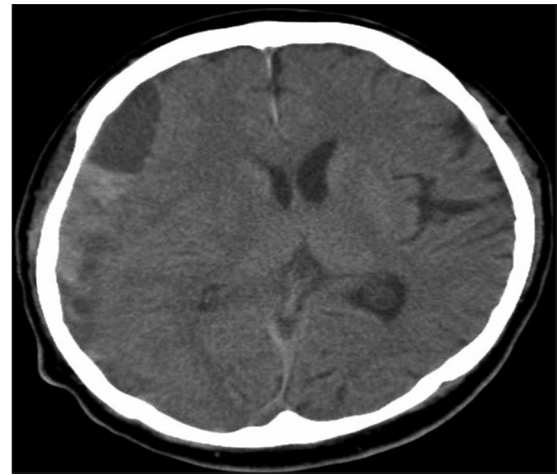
Axial noncontrast CT brain obtained preoperatively shows a right-sided acute-on-chronic SDH
